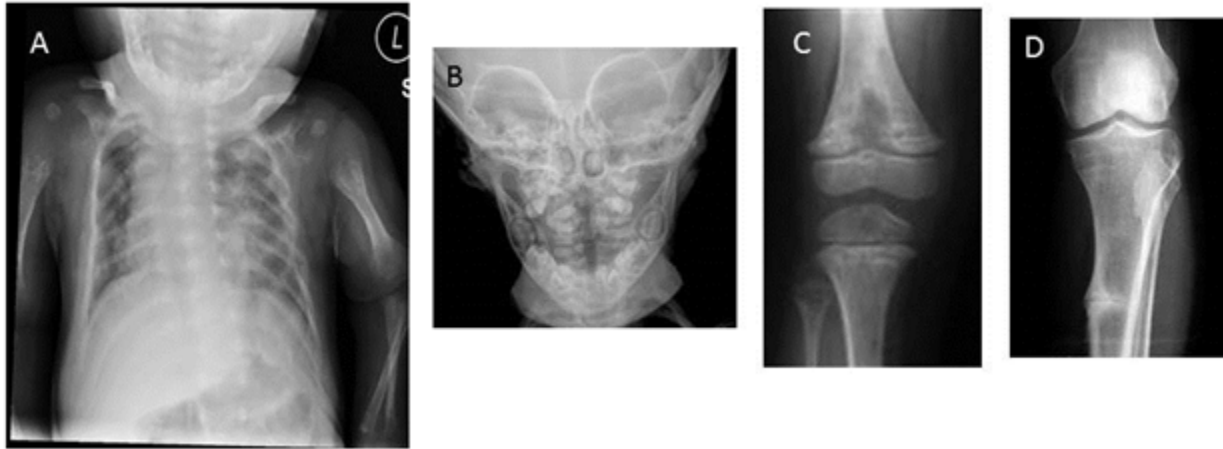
Radiographic signs of hypophosphatasia
